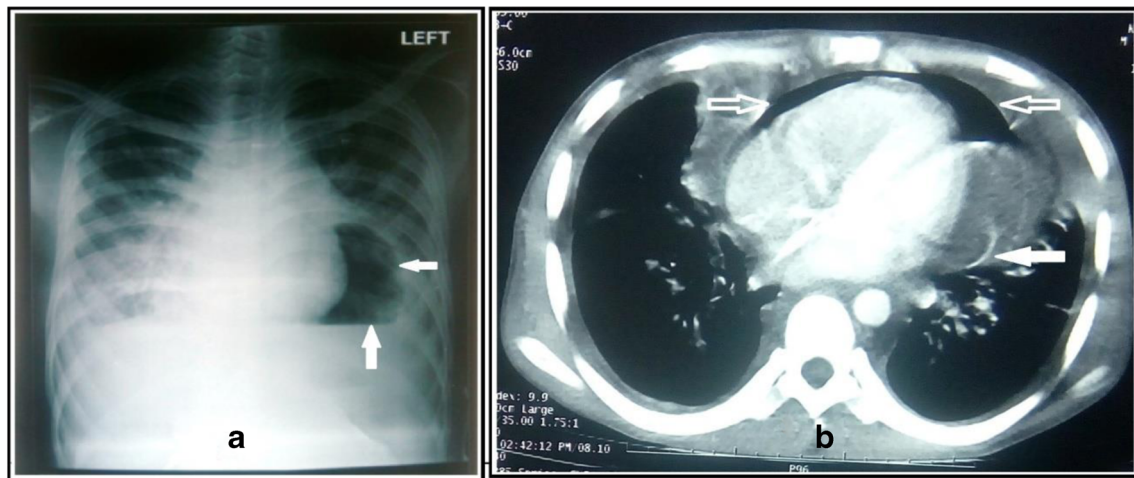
a Chest X-ray showing pericardial halo of air with air fluid level (arrow). b CECT showing pneumopericardium (arrow) with loculated effusion and pigtail catheter in situ (solid arrow)
